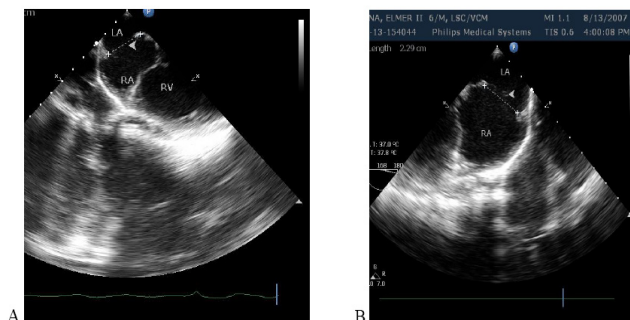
Measurement of the ASD diameter and septal margins via intraoperative transesophageal echocardiography: (A) Horizontal plane or the four chamber view and (B) vertical plane or the bicaval view.
